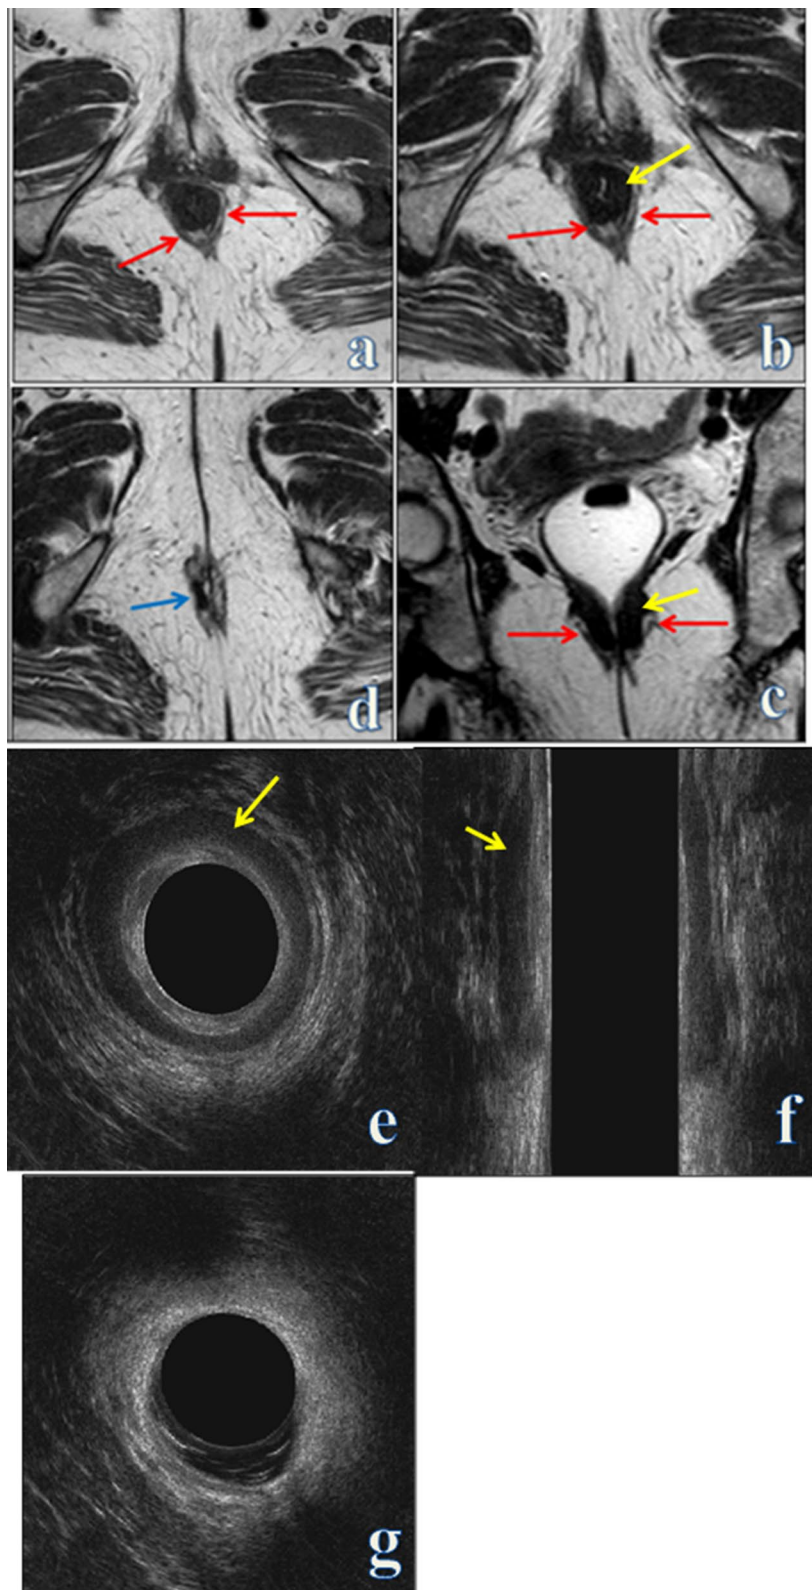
a axial T1 and b, d axial T2WI, c coronal T2 WI MRI images show diffuse thinning out/atrophy of EAS (red arrows), d axial T2 at lower level shows a right sided EAS dark T2 signal scar at 9 O'clock (blue arrow) e axial and f coronal reconstructed EAUS images couldn't detect EAS atrophy, g axial image at lower level couldn't detect the right sided EAS scar. The IAS (yellow arrows) appears thickened (8 mm) and foreshortened
